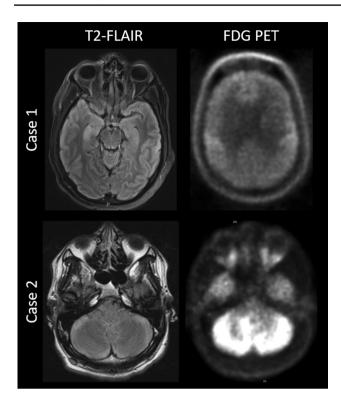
Representative brain magnetic resonance and fluorodeoxyglucose positron-emission tomography imaging from AMPAR encephalitis patients. Axial magnetic resonance T2 fluid-attenuated inversion recovery (FLAIR) images (left) are shown alongside of fluorodeoxyglucose positron-emission tomography (FDG-PET) images (right) from exemplar cases presenting with AMPAR encephalitis. In case 1, T2-FLAIR reveals bilateral, right greater-than-left hippocampal hyperintensities. FDG-PET demonstrates global hypometabolism with sparing of bilateral motor cortices. Case 2 demonstrates T2-FLAIR hyperintensities in the bilateral cerebellum, with corresponding FDG-PET hypermetabolism
